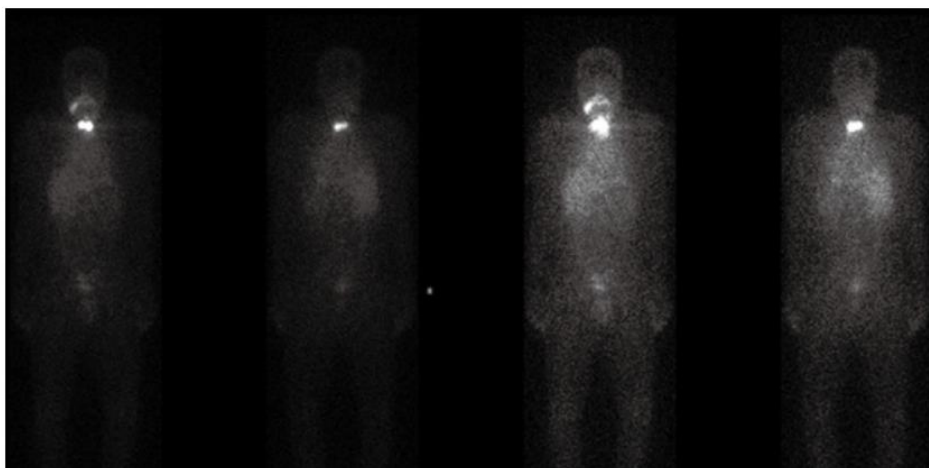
A 39-year-old male patient diagnosed with metastatic papillary thyroid carcinoma. Patient presents ¹³¹Iodine uptake in I-SPECT scan.
